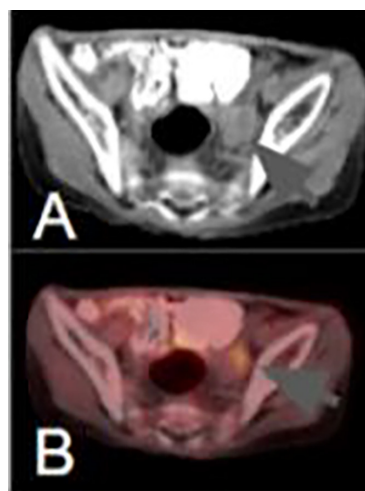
A. MRI image showing recurrent retroperitoneal tumor near iliac vessels and bladder. B. Preoperative PET-CT image demonstrating pathological FDG uptake near the left bladder and lymph nodes.
